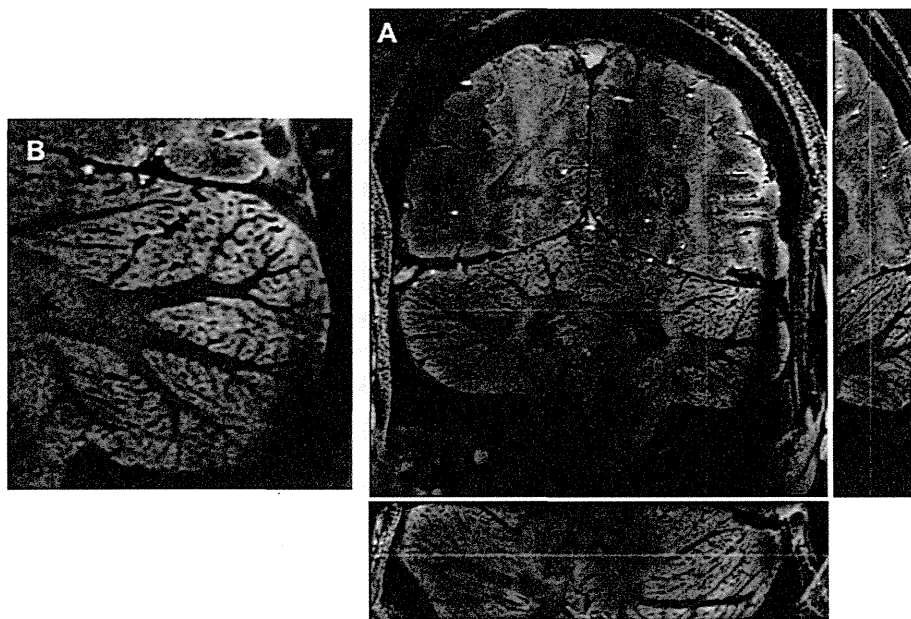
MRI of cerebellum at 9.4 T. (A and B) Phase and magnitude images of fixed tissue. The granular and molecular layers have distinct phase,  $T_2^*$  and  $M_0$  contrast. (C and D) *In vivo* imaging at 9.4 T using a 2D multiple-echo gradient echo sequence. Anisotropic resolution of  $0.2 \times 0.2 \times 1.5 \text{ mm}^3$ . TR = 120 ms, TE = 6.5 ms (C), 17.5 ms (D),  $70^\circ$ . At closer inspection, in regions where the slice orientation is favourable, the cerebellar grey matter shows two layers with distinct  $T_2^*$  properties.
